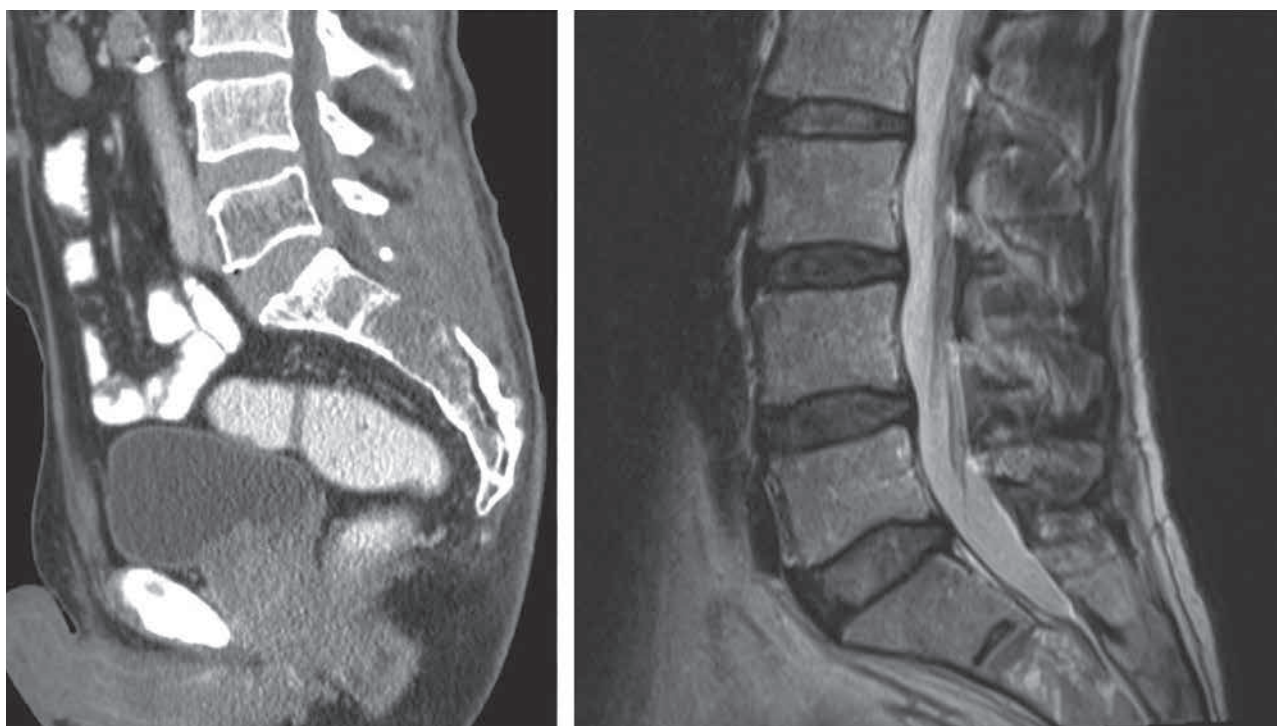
CT and MRI with the tumoral mass of S2-S3, spreading to sacral neuroforamina
